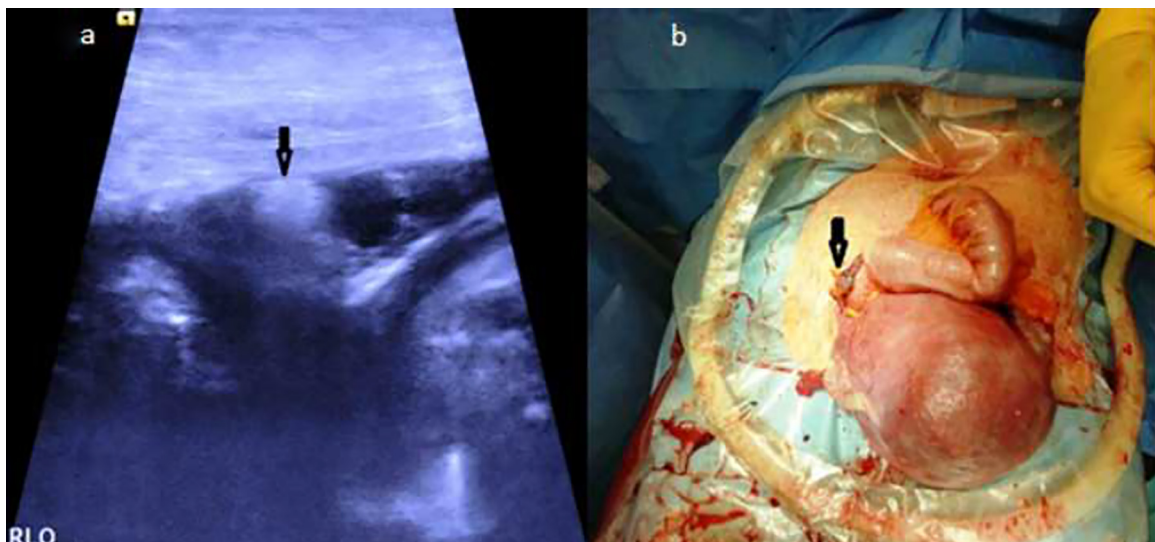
a: Hyperechoic thickened epiploic appendagitis on ultrasonography, b: epiploic appendagitis attached to the rightly displaced sigmoid.
